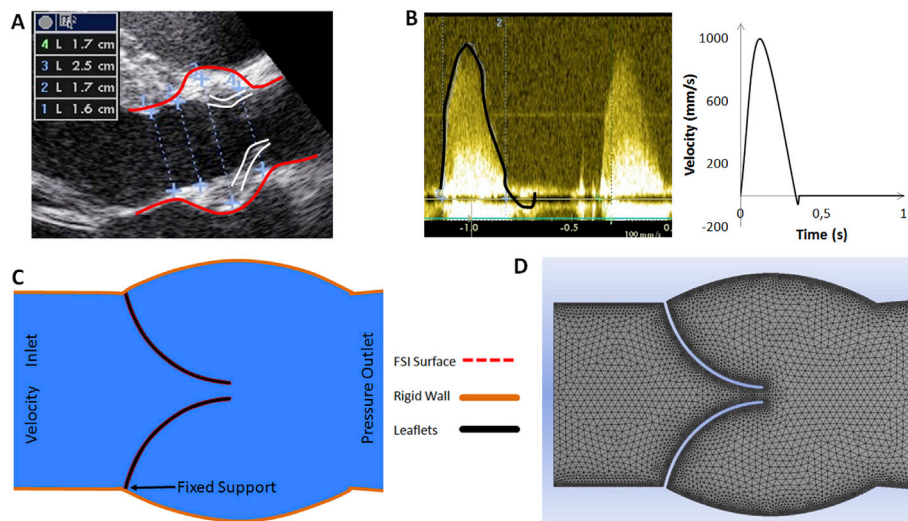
Model geometry generation. A. Dimensions of an aortic valve were determined from the short axis b-mode views. B. Doppler velocity measurements for the same valve (left) were defined as the inlet transient velocity boundary condition (right) in the model. C. Geometry was generated in ANSYS Workbench and boundaries and zones are defined. D. Fluid zone (blood flow) and structure zone (leaflets) are meshed separately.
